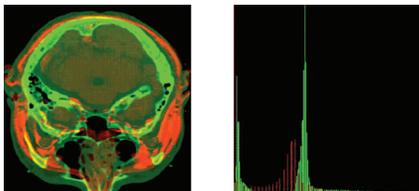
Overlap of CT (green) and MRI (red) scans and intensity profiles before permutation and histogram matching.
